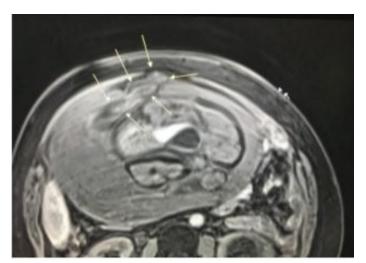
Coronal T2-weighted MRI of the maternal abdomen showing the uterine defect with the protruding fetal arm.
